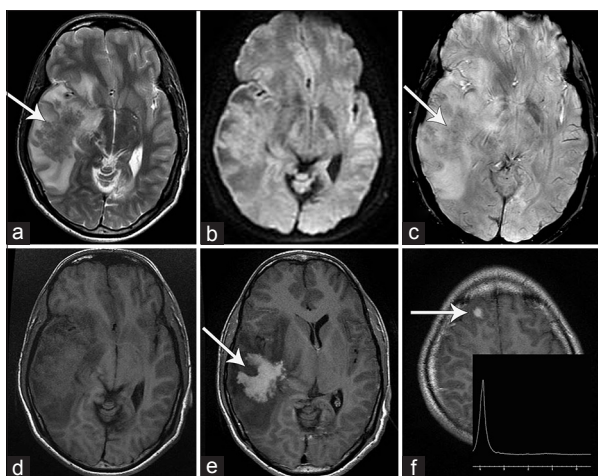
(a) T2-weighted image shows a hypointense mass (arrow) in temporal lobe with marked perilesional edema. (b) Diffusion-weighted image does not reveal diffusion restriction. (c) Lesion shows mild blooming (arrow) on susceptibility-weighted image. (d) Lesion is isointense to gray matter on noncontrast T1-weighted image. (e) Lesion shows homogeneous intense postcontrast enhancement. Margins of lesion are irregular with frond-like projections (arrow). (f) Another enhancing nodular lesion noted in the right frontal lobe (arrow). Inset show peak at 3.8 ppm on MRS from the temporal lobe lesion
